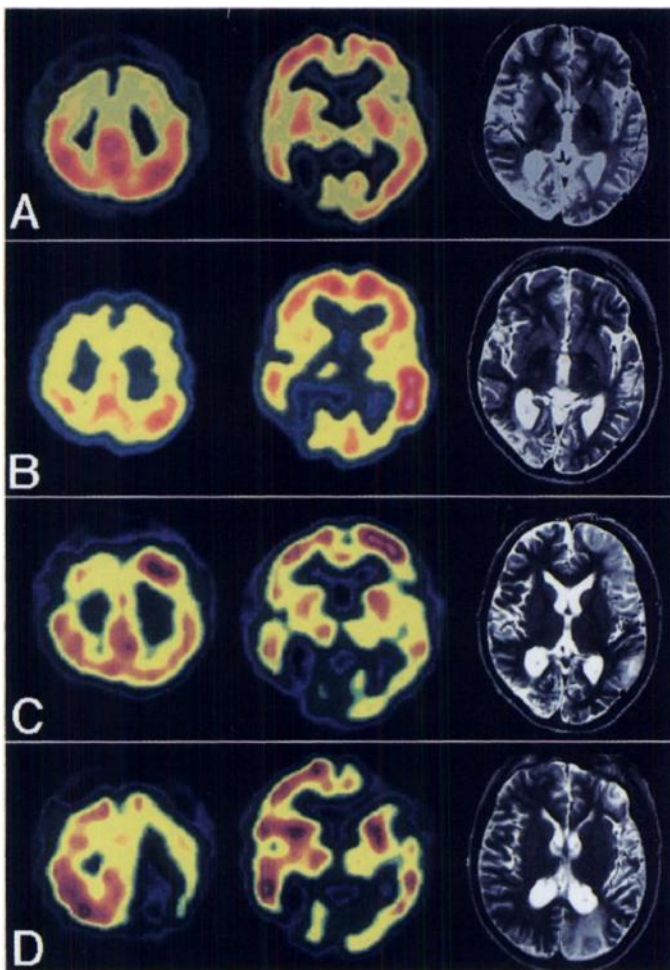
Sequential ^{99m}Tc -HMPAO (A, C and D) and ^{123}I -IMP (B) SPECT and T2-weighted MRI in MELAS (Patient 3). (A) SPECT shows hypoperfusion in right occipital lobe. MRI shows a T2 prolonged area at right occipital lobe. These findings are observed in all studies of Patient 3. (B) Sixteen months after A, SPECT shows hyperemia in left parietotemporal region. MRI shows no corresponding areas of signal abnormality. (C) Five months after B, SPECT shows hyperemia in left frontal lobe. MRI shows T2 prolonged area with swelling predominantly involving cortex of left frontal lobe. (D) Three months after C, Some areas of left frontal hyperemia have progressed to infarction and new lesions are observed in left parietooccipital region.
